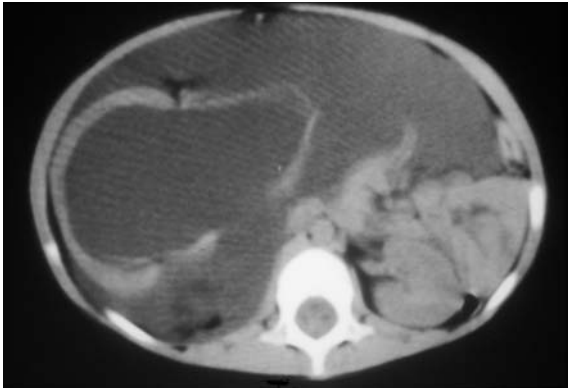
CT scan demonstrating a grossly dilated right kidney with a thin rim of renal cortex. This kidney has ruptured after trauma, leading to extensive extravasation.
